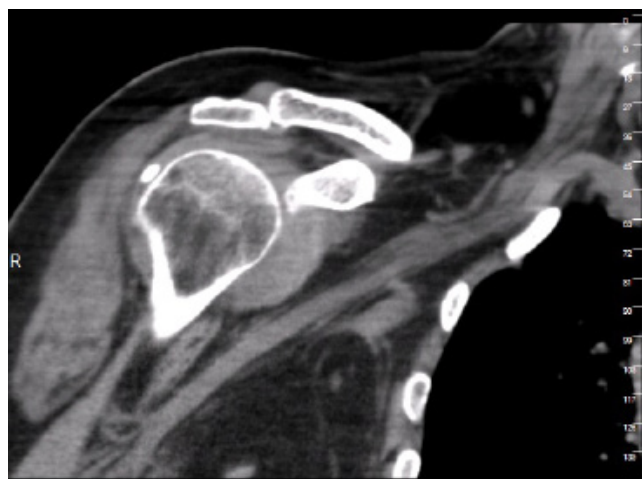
Computed tomography image of calcification in the area of insertion of the infraspinatus.
